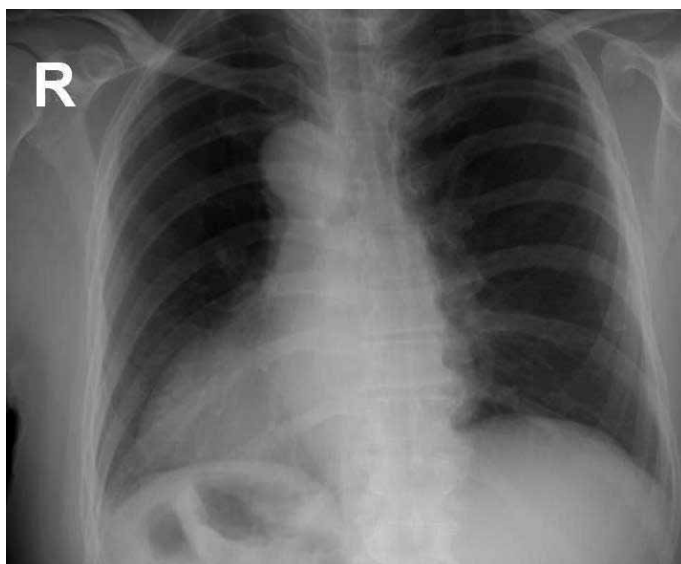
Chest radiographic image confirming dextrocardia with right-sided aortic arch and right-sided gastric bubble
